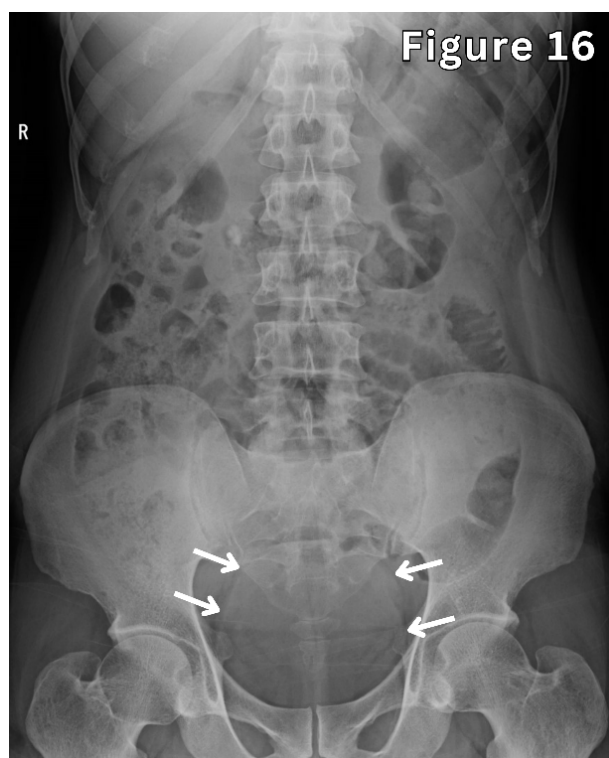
A 52-year-old patient with a history of bladder outlet obstruction. Abdominal X-ray shows a distended urinary bladder, likely due to chronic retention.
